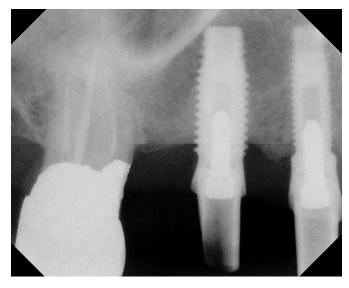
Periapical radiograph demonstrated an intimate metal-tometal fit between the abutments and implants. The sub-gingival emergence profiles were fabricated by the CAD computer software program and milled by the CAM milling unit.
